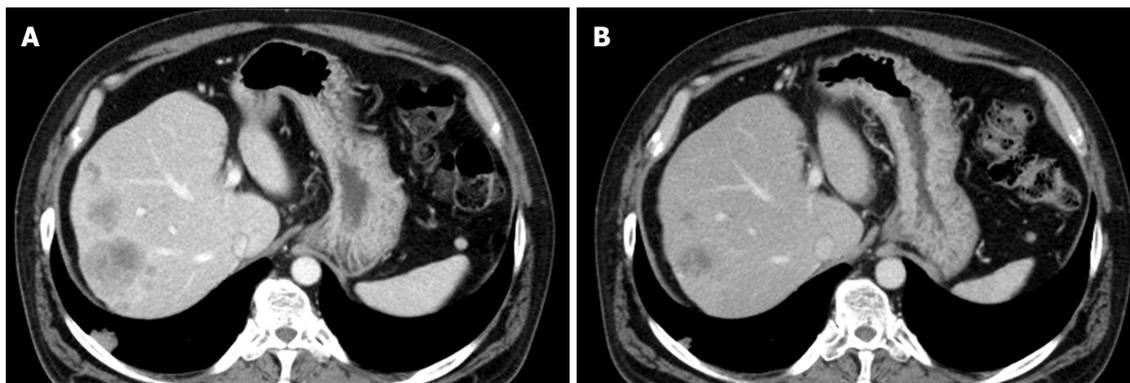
Effect of anti-epidermal growth factor receptor antibody on liver metastatic lesions of colon cancer. A: Enhanced abdominal computed tomography showed metastatic lesions throughout the liver, including in the right posterior segment; B: The best response was partial response, with eventual regrowth.
